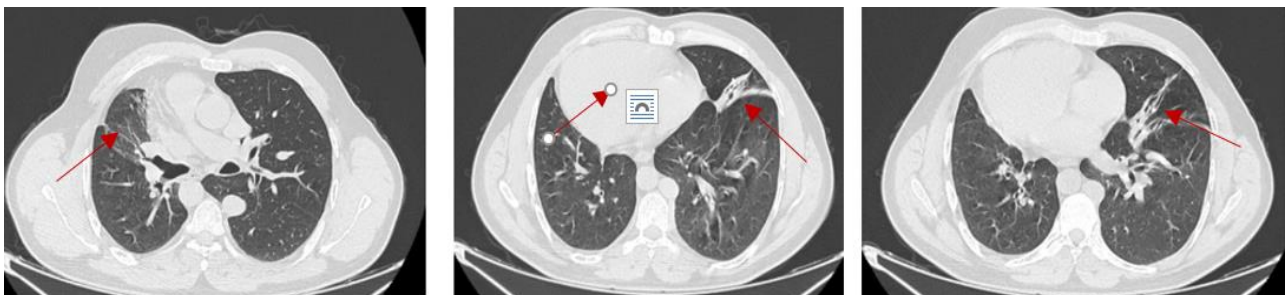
a: Chest CT axial section in parenchymal window: presence of bilateral cylindrical and moniliform pulmonary bronchiectasis in the middle lobar and lingular areas, with a focus of condensation in the left lung with an air bronchogram
